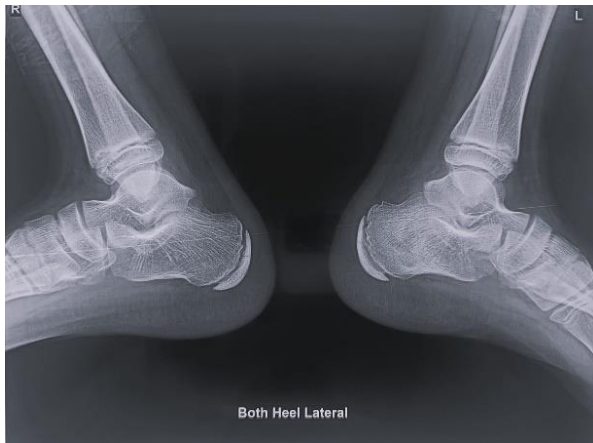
Preoperative X-ray showing a small lytic lesion in the posterior aspect of left calcaneum with associated surrounding rim of sclerotic changes. No radio-opaque structure is seen within the soft tissue of the ankle.
